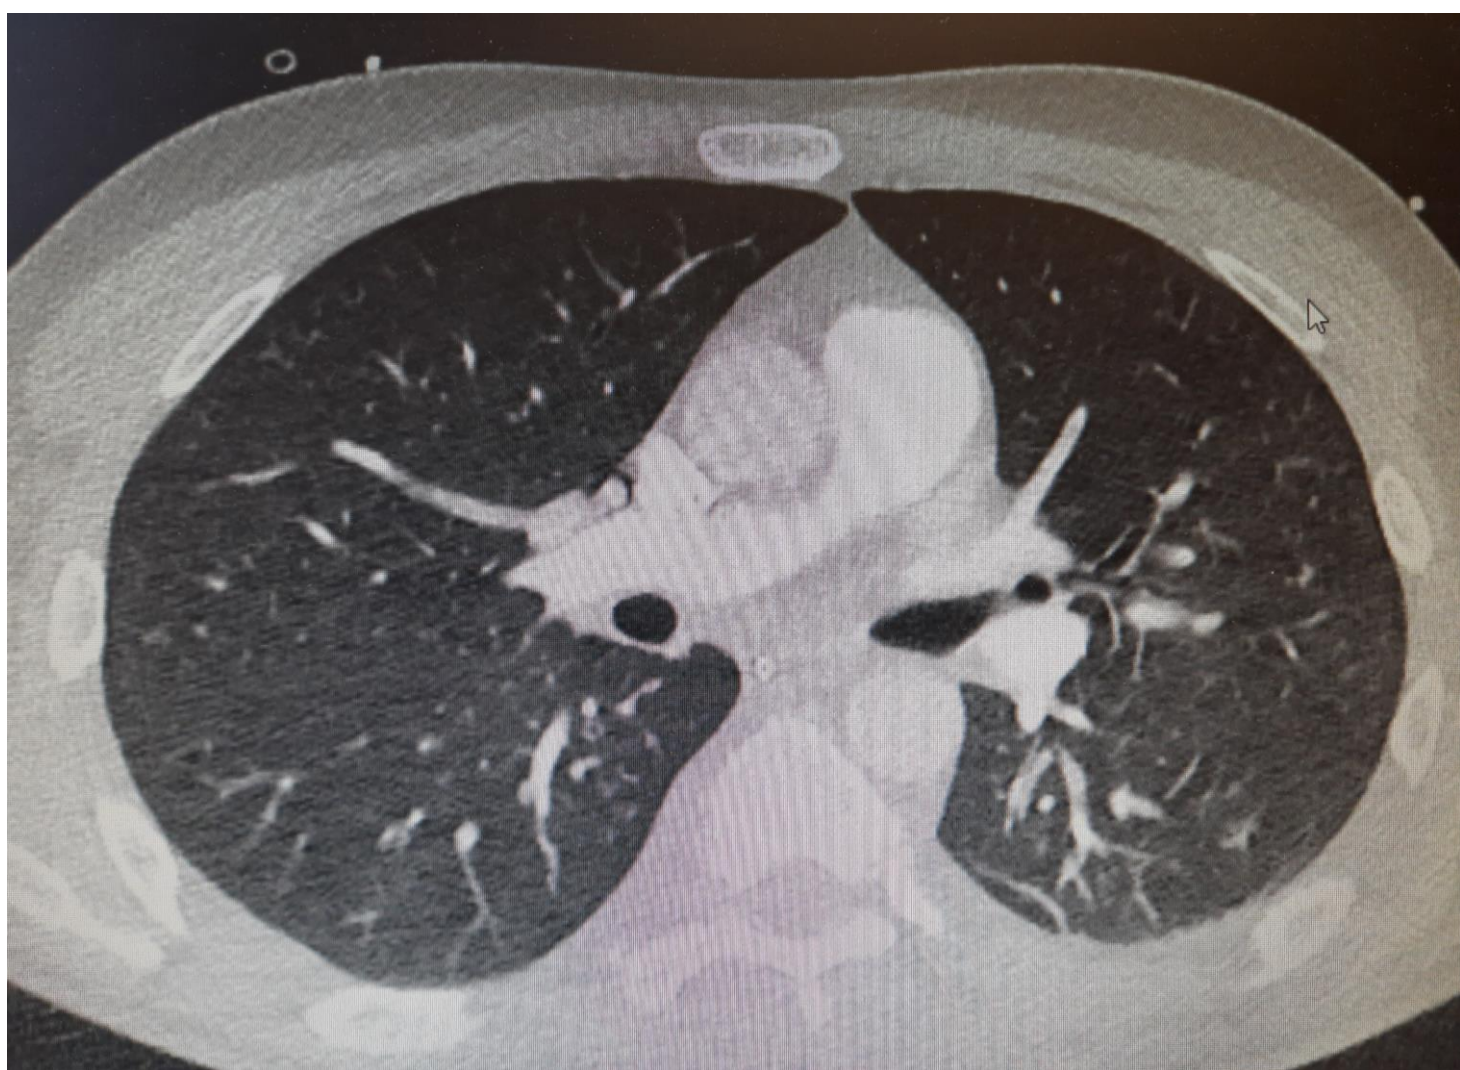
Day 9: CT Pulmonary angiogram: Normal lung parenchyma & no evidence of pulmonary embolism
